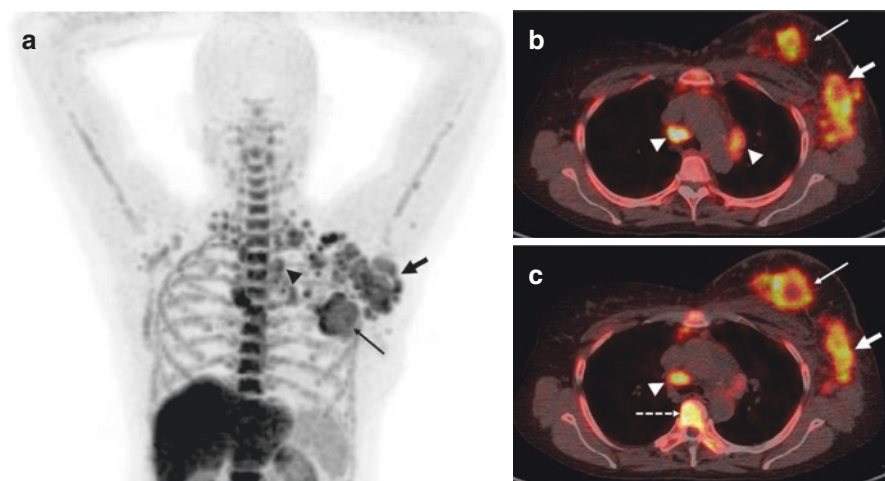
A 50-year-old-woman presented with newly diagnosed carcinoma left breast (Infiltrating ductal carcinoma, grade III; T4bN3Mx). ^{18}F -FLT PET/CT maximum intensity projection (MIP) image (a), and transaxial fused PET/CT images (b, c) show increased tracer uptake, suggestive of high cellular proliferation in the primary breast mass (solid thin arrow), enlarged left axillary lymph nodes (solid thick arrow), mediastinal lymph nodes (arrow-heads) and skeletal lesions (dashed arrow), representing metastatic disease. Physiological radiotracer uptake is also seen in the liver, spleen, kidneys and bone marrow in the MIP image
